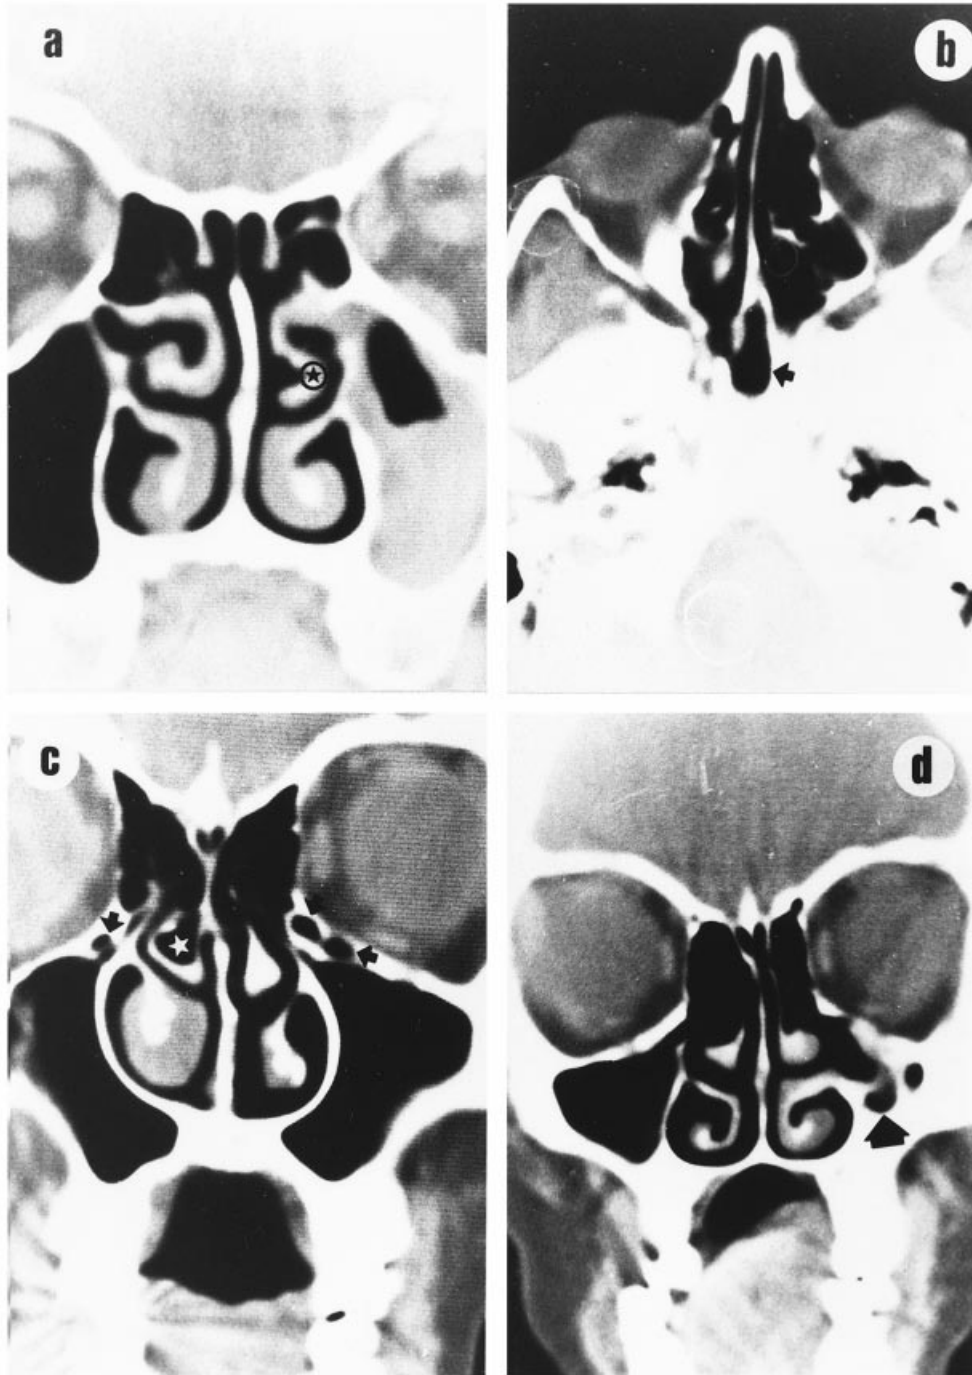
CT images of some of the nasal sinus anatomical variants found. (a) Coronal scan: paradoxical middle nasal concha (black star); (b) horizontal scan: Onodi air cells (arrow); (c) coronal scan: bilateral Haller air cells (arrows); a concha bullosa is also seen on the left, marked by a white star; (d) coronal scan; hypoplasia of the right maxillary sinus (arrow) accompanied by absence of the unciniate process.
